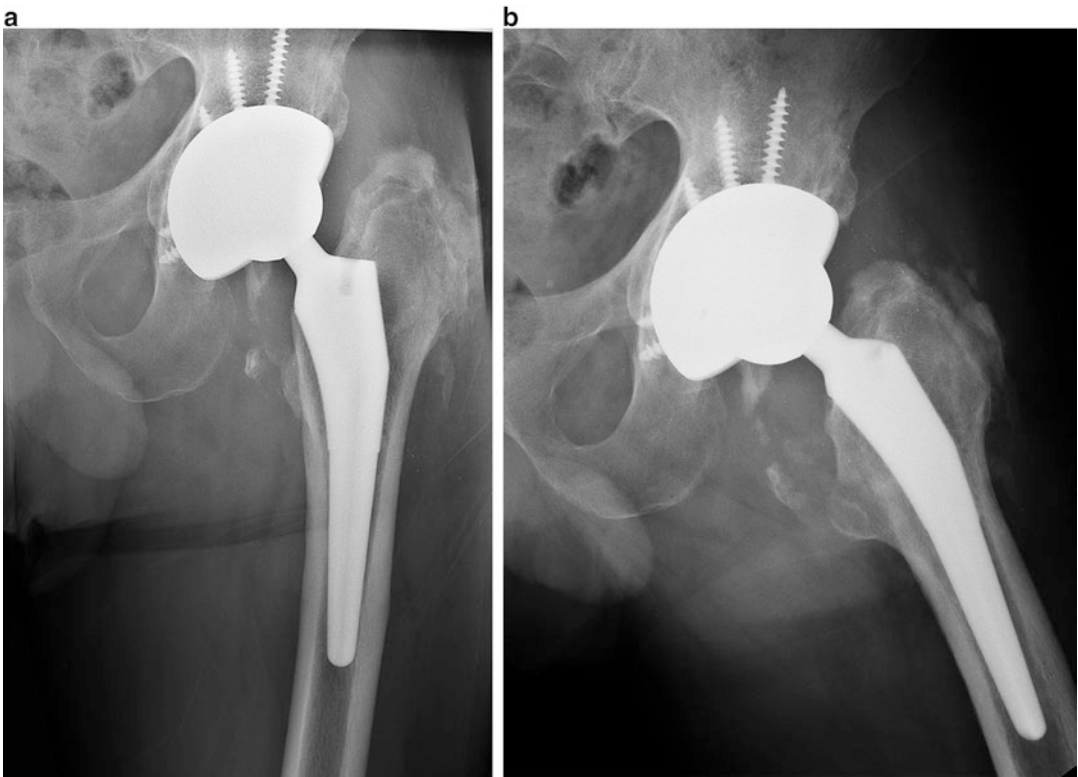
(a) AP radiograph, (b) frog leg lateral radiographs of left total hip arthroplasty after removal of heterotopic bone
